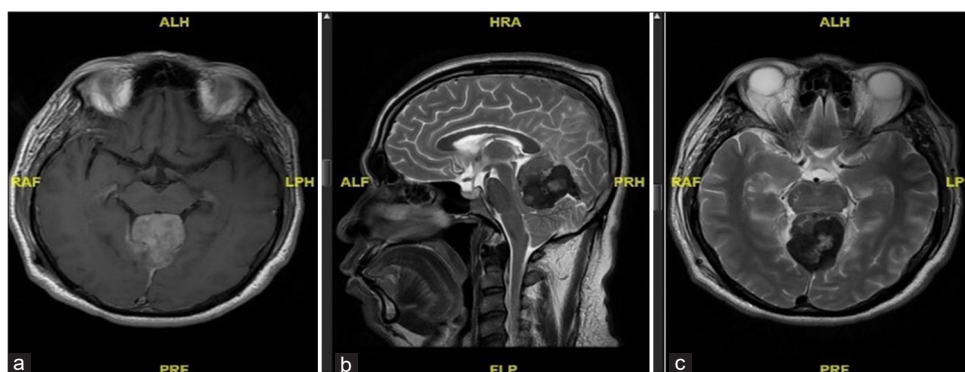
(a) Preoperative magnetic resonance imaging (MRI) T1-weighted axial view. (b) Preoperative MRI T2-weighted sagittal view. (c) Preoperative MRI T2-weighted axial view.
